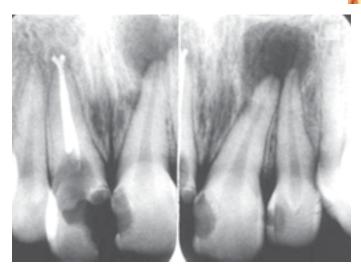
Periapical abscess—Well-defined radiolucency of anterior teeth
